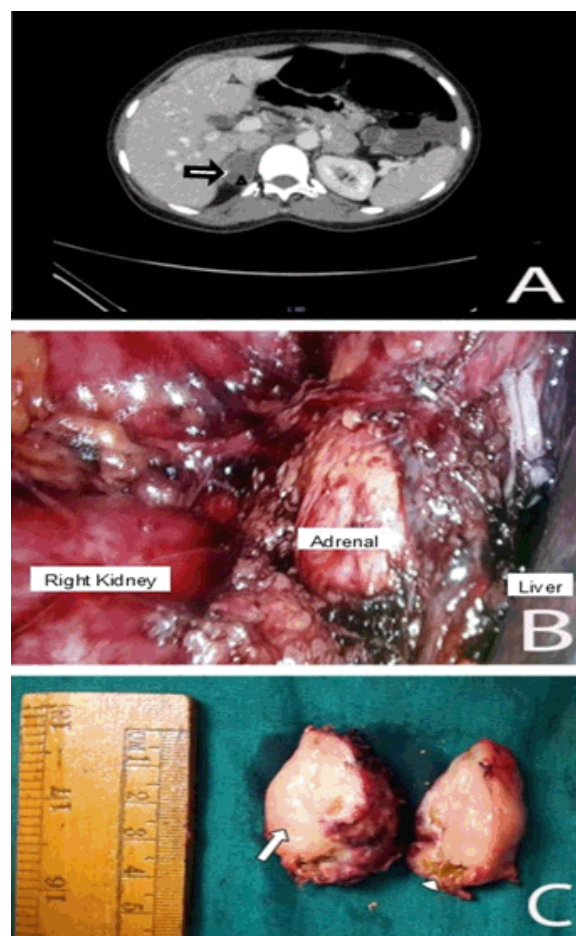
(A) Computed tomography scan of abdomen and pelvis showing right adrenal mass (arrow) with calcifications, (B) Intraoperative picture showing the adrenal mass in relation to the kidney and the liver, (C) Cut section revealing Greyish white surface of tumor (arrow) with small arrowhead showing adrenal parenchyma.
